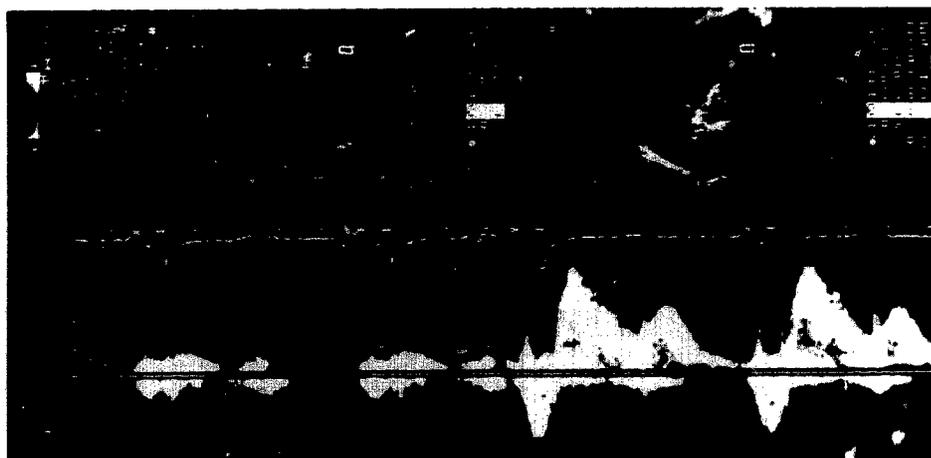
Original pulsed Doppler recording of pulmonary venous flow from an apical transducer position. Left, Note the signal-to-noise ratio preventing any quantitative analysis. Right, With contrast enhancement the signal-to-noise ratio improves, and flow traces have clear envelopes.
